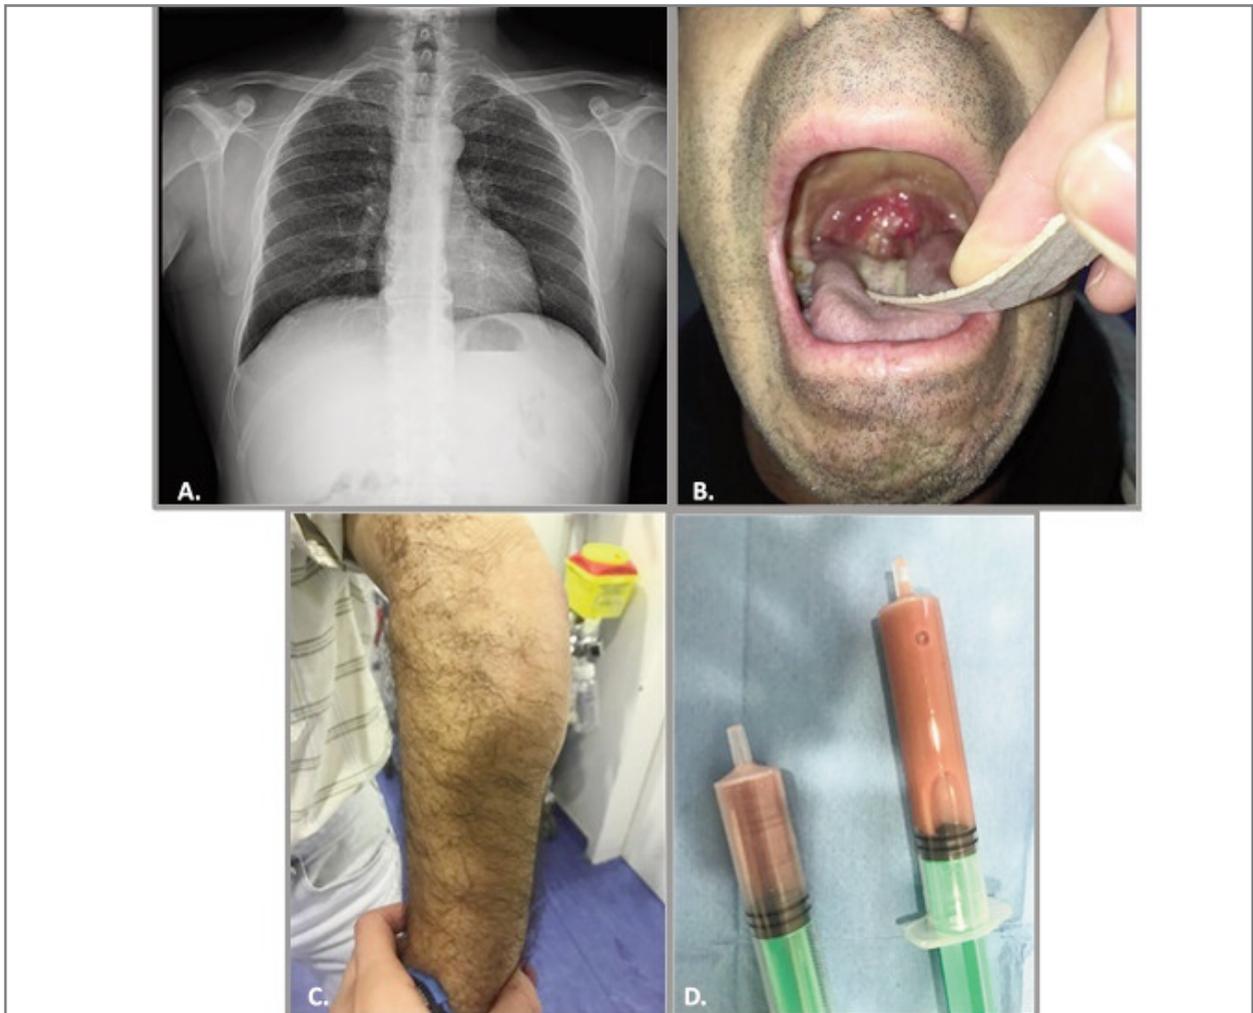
Case 4. A. PA chest x-rays demonstrate wide spread small nodular opacities distributed throughout both lungs; B. Tonsillar hypertrophy and exudate (with isolation of *M. tuberculosis* in oropharynx exudate); C. Olecranon bursitis (*M. tuberculosis* isolation in synovial fluid); D. Synovial fluid of olecranon bursitis.
